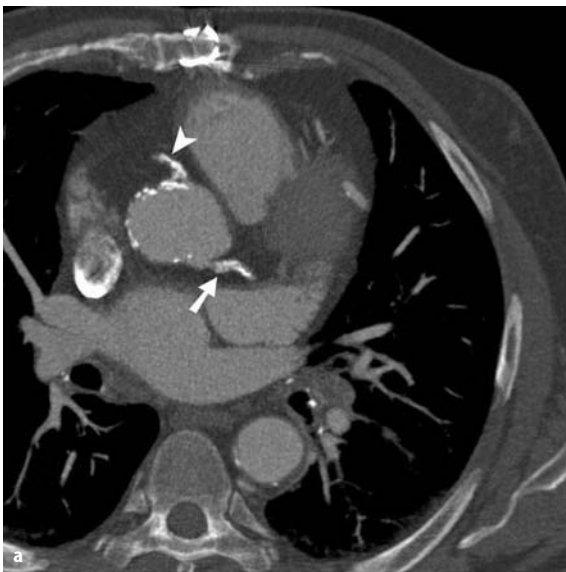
a Axial CT; aortic root with heavily calcified right (arrowhead) and left (arrow) coronary arteries; the ostium of the right coronary artery is located in the anterior Valsalva sinus.
